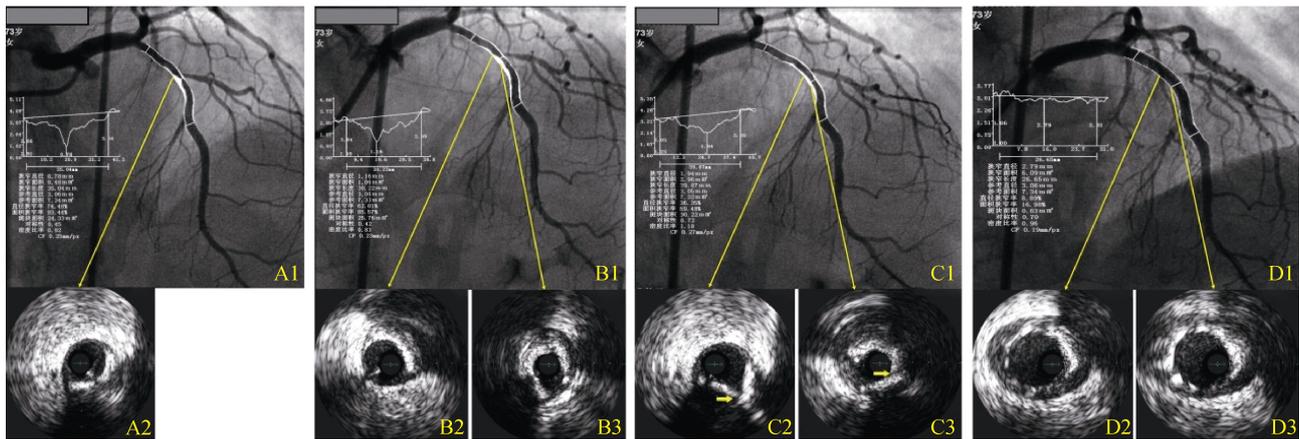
A case of severely calcified lesion treated by RA combined with CB. (A1): the lesion lumen diameter and stenosis measured by QCA pre-PCI; (A2): IVUS probe cannot pass the serious stenosis and was stunned at the proximal segment. There was a 180° calcified ring; (B1): the lumen diameter increased and stenosis was decreased after RA, and IVUS could pass the lesion; (B2 and B3): superficial calcified rings; (C1): the lumen stenosis was further decreased after CB; (C2 and C3): the calcified ring was broken as the arrow shown; (D1, D2 and D3): the final result after stent implantation, without stent underexpansion or malposition. CB: cutting balloon; IVUS: intravascular ultrasound; PCI: percutaneous coronary intervention; QCA: quantitative coronary angiography; RA: rotational atherectomy.
